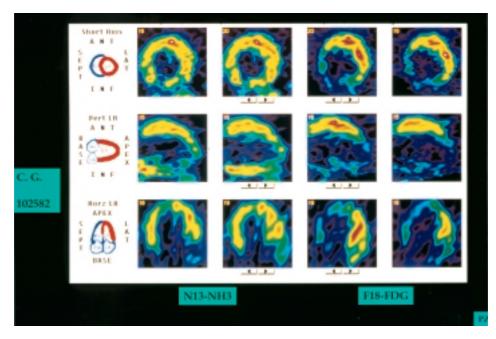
Patient with dual chamber pacing pacemaker: a clear defect in ¹⁸F-fluorodeoxyglucose (FDG) uptake in the septum and inferior wall, not associated with a defect in perfusion, is present. On the left ¹³N-ammonia (NH3), on the right ¹⁸F-FDG; top panels: midventricular short-axis slices, middle panels: midventricular vertical long-axis slices, bottom panels: midventricular horizontal long-axis slices.
